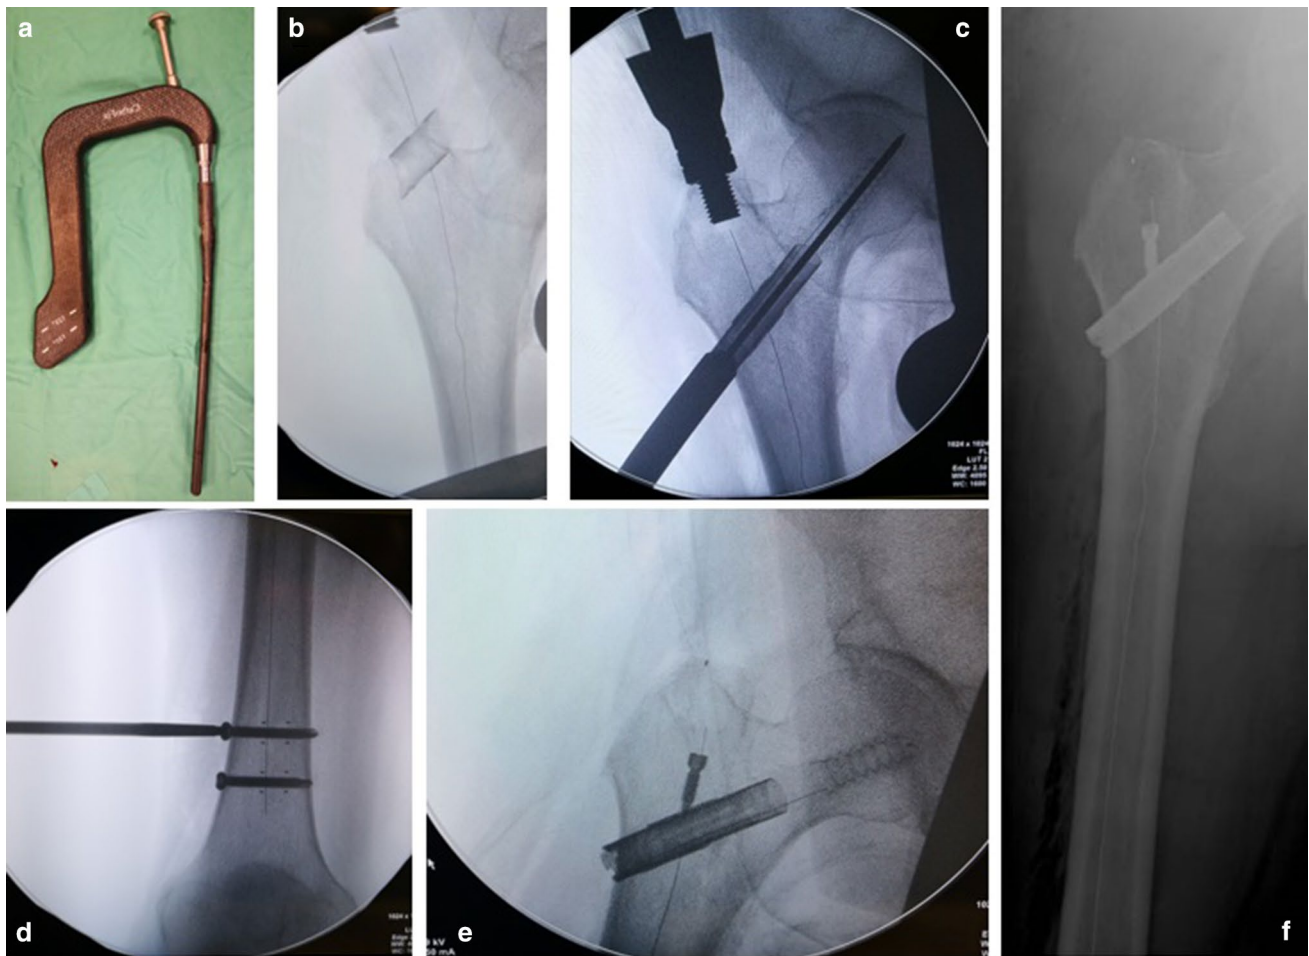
Multiple myeloma metastasis in right femur. Intraoperative images showing CarboFix implant and the relative procedure (a–e); post-operative X-rays (f)
